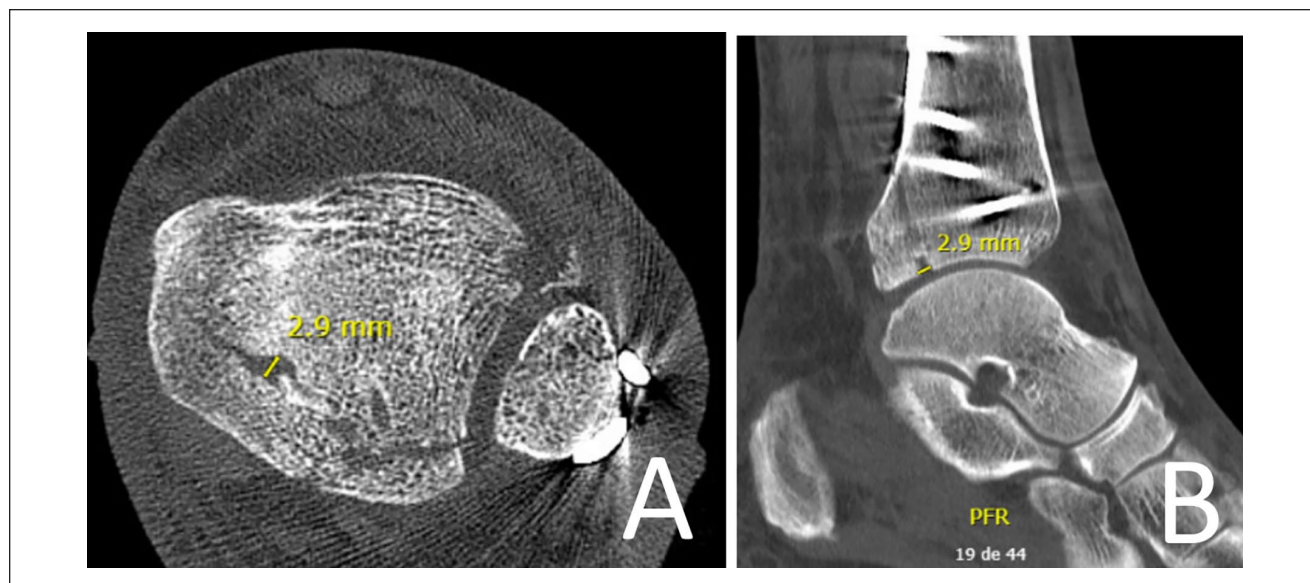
Coronal and sagittal computed tomographic scan showing how we measure articular gap. (A, B) Articular gap secondary to nonresection and nonreduction of intercalary articular fragment.
